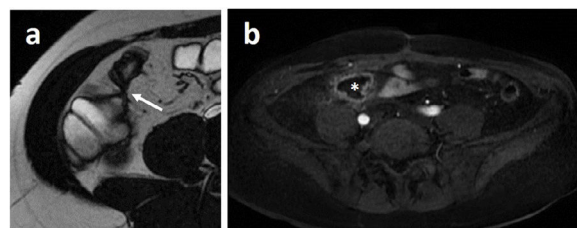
Axial plane MRE images, very useful for detecting penetrating disease and extraintestinal abnormalities. a) T2-weighted SSFP sequence showing an ileocolic fistula (*arrow*). b) 3D T1-weighted sequence with IV contrast. A hypointense mesenteric collection can be seen with peripheral enhancement (*asterisk*) compatible with an abscess.
